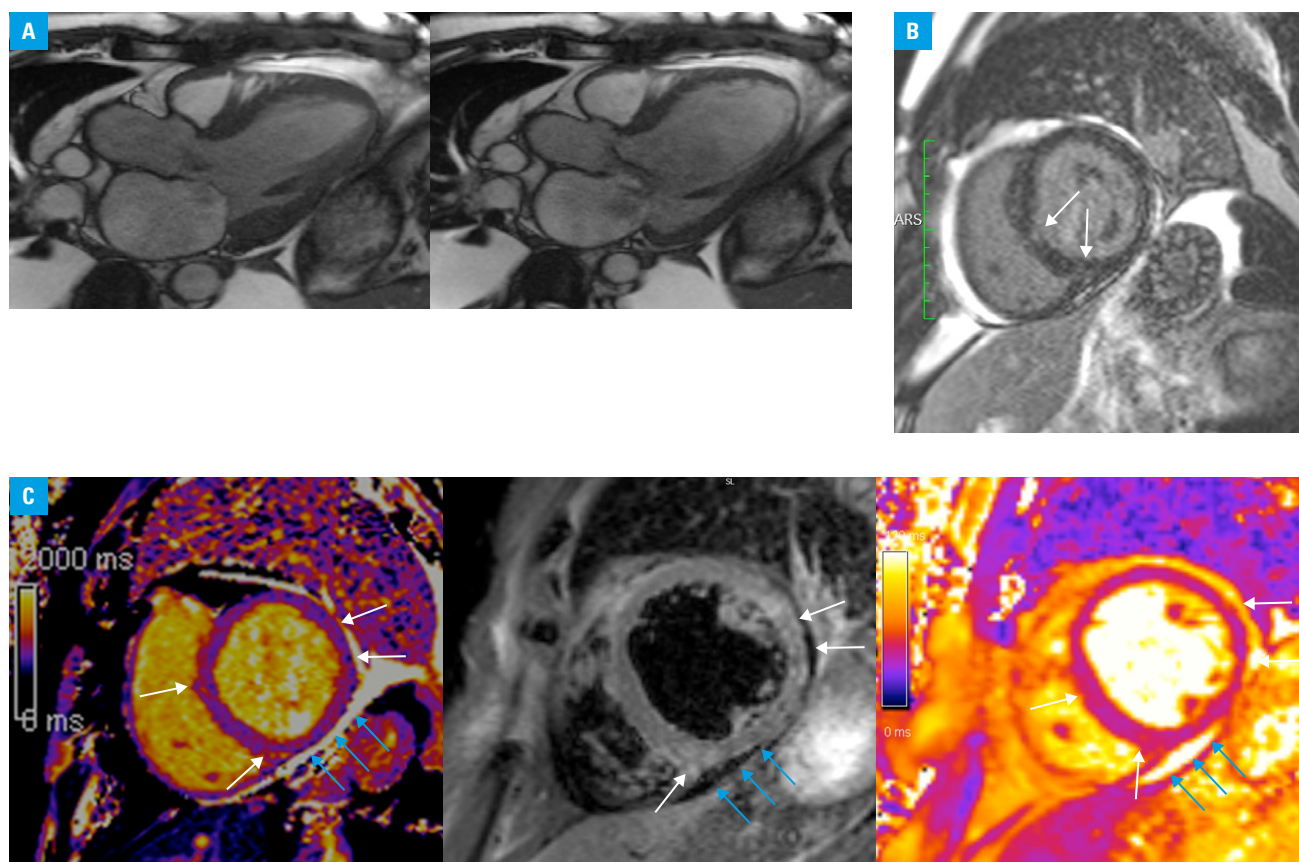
Cardiac magnetic resonance imaging with a Siemens Aera 1.5T device (Erlangen, Germany); A – long axis systolic (left) and diastolic (right) still frames from routine cine balanced steady-state free precession sequence showing slight left atrial and marked left ventricular enlargement (left ventricular end-diastolic volume index of 169 ml/m²), with severe aortic insufficiency (registration volume in a phase-contrast sequence: 65 ml/cycle) and moderately reduced left ventricular ejection fraction (45%); B – late gadolinium enhancement; phase-sensitive inversion recovery sequence: minimal subendocardial/intramural late gadolinium enhancement in mid-infero-septal and inferior segments (arrows); C – parametric mapping showing inhomogeneous myocardium with local areas of increased native T1 relaxation time (white arrows on the left panel; local native T1 increases up to 1110 ms; reference range, 951–1035 ms; basal short axis slice, images acquired with a modified Look-Locker inversion recovery sequence) and locally increased signal in the T2 weighted short tau inversion recovery sequence pointing to patchy edema (white arrows on the middle panel; mid-ventricular slice), matching the areas of locally elevated T2 time predominantly in the septal and infero-lateral segments (white arrows on the right panel; local increases up to 54 ms; reference range, 39–49 ms; images acquired with a balanced steady-state free precession sequence). This is suggestive of inhomogeneous diffuse acute injury due to myocardial involvement. Small pericardial effusion is apparent in all 3 images (blue arrows).
